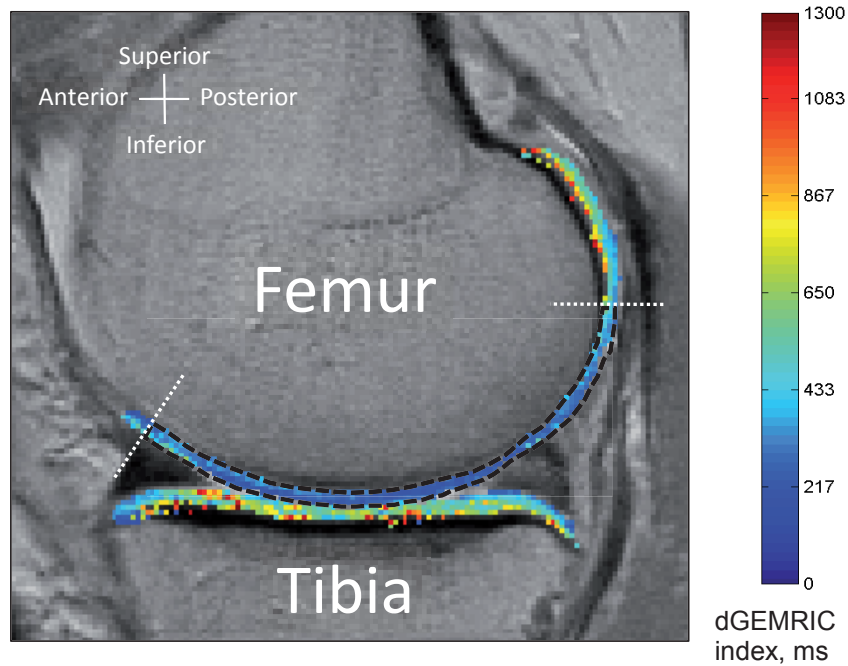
Cartilage region-of-interest (ROI) in a single sagittal slice from the center of the medial femoral condyle. The ROI is confined across full-thickness cartilage from the outer edge of the anterior horn of the meniscus to the midpoint of the posterior femoral cartilage, as outlined by the dashed lines. In delayed gadolinium enhanced MRI of cartilage (dGEMRIC) high values correspond to high glycosaminoglycan (GAG) content and low values correspond to reduced GAG content.
